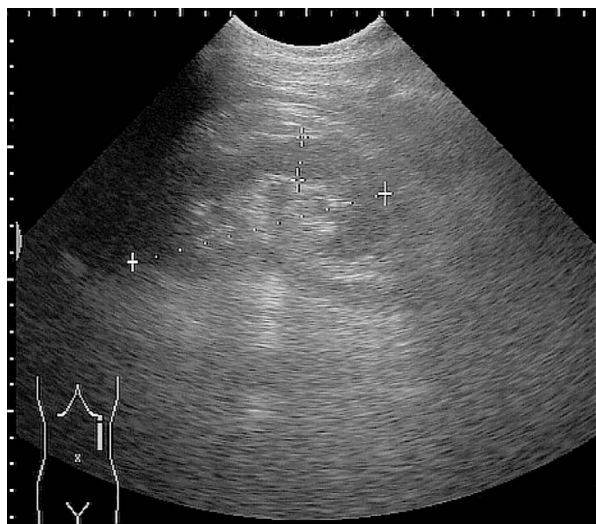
Sonogram of the kidney. Mild left hydronephrosis with minimal perirenal anechoic fluid collection.
